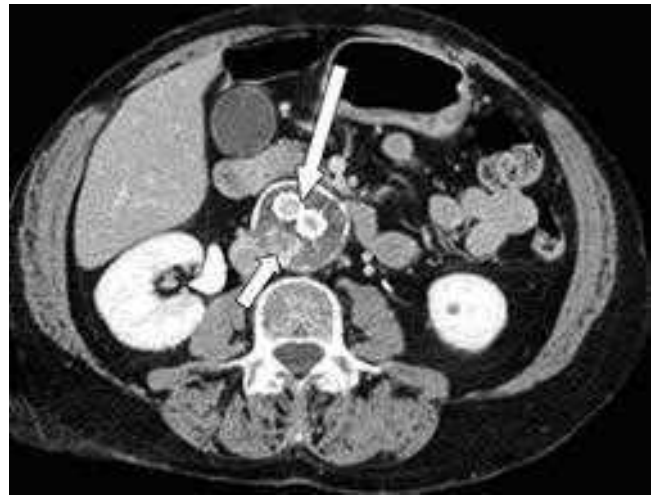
A computed tomography scan demonstrating an endoleak (*small arrow*) as evidenced by contrast flow outside the aortic endograft (*long arrow*).
